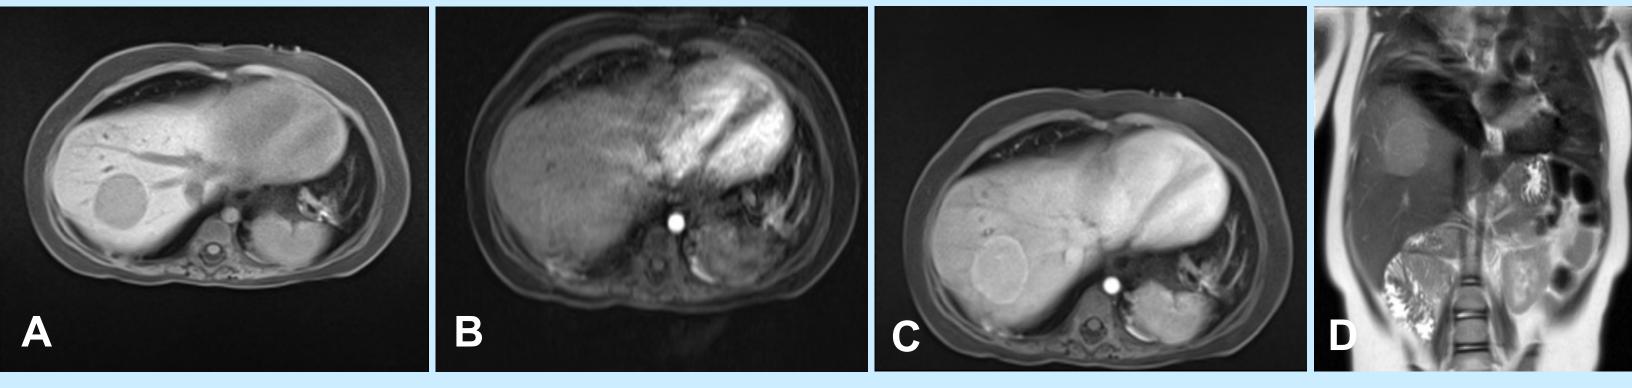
MRI demonstrating the segment VII HB with (A) T1 pre contrast hypointensity, (B) T1 arterial phase contrast isointensity, (C) and T1 venous phase contrast hyperintensity. (D) Coronal T2 images demonstrate typical hyperintense appearance of HB compared to background liver.
